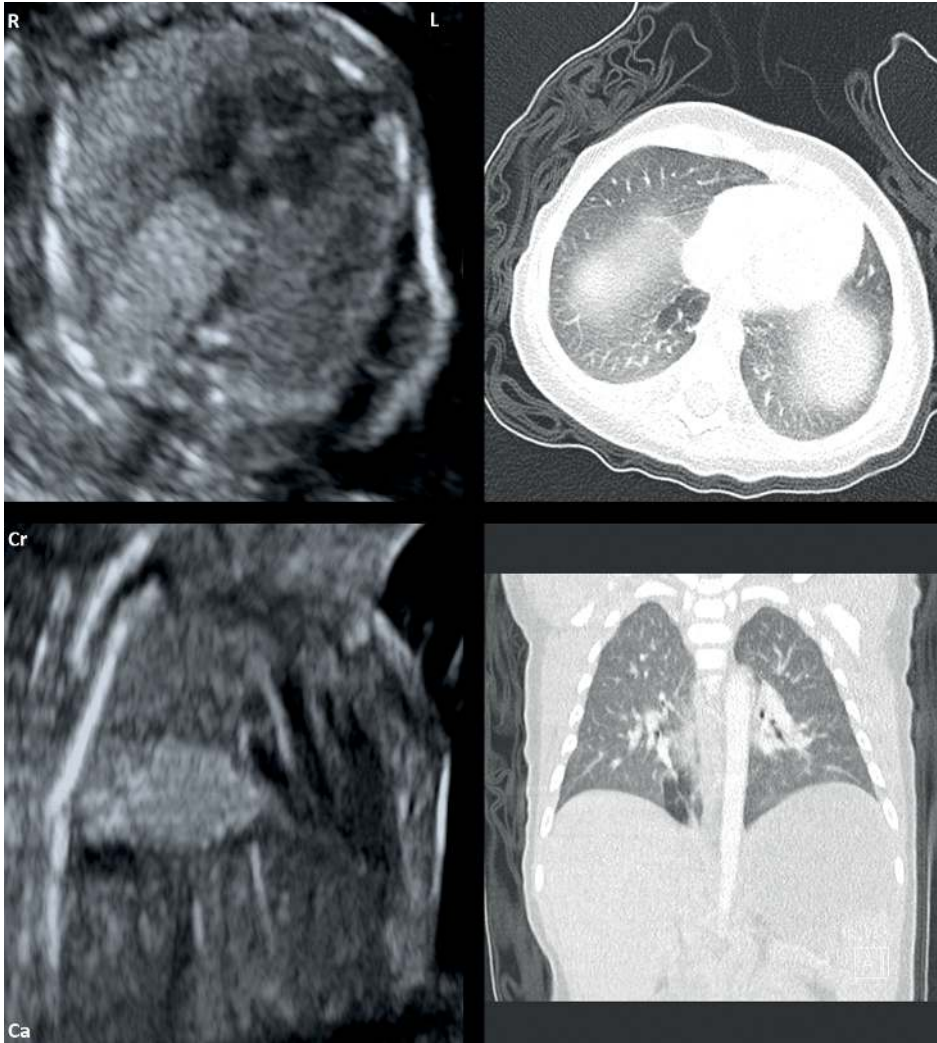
Abbreviations: BPS, bronchopulmonary sequestration; Ca, caudal; CPAM, congenital pulmonary airway malformation; Cr, cranial; CVR, CLM volume ratio; L, left; R, right; US, ultrasound.
